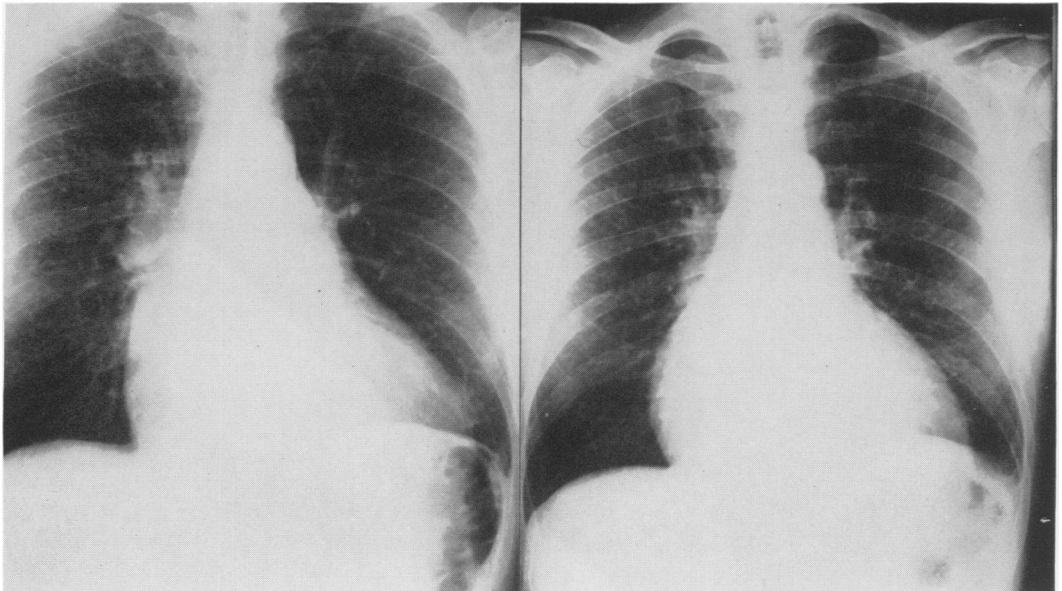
(Case 4). Preoperative x-ray and x-ray 20 months following surgery. This patient is asymptomatic and has no murmur.
